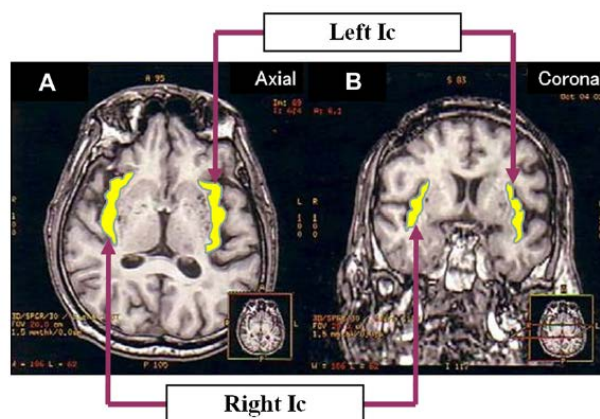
Axial and coronal views of a brain using magnetic resonance imaging. Yellow color represents the insular cortex⁽³¹⁾.
